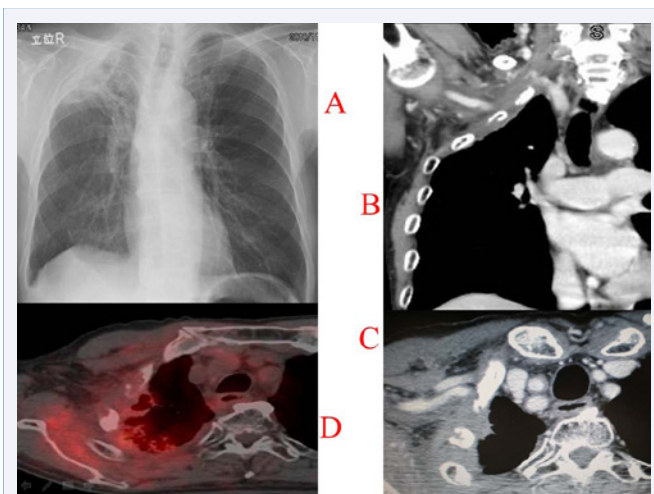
The (A) plain chest radiograph and (B, C) CT images indicate good partial response after the induction chemoradiotherapy. (D) The tumoral SUV_{max} decreased to 3.1.
